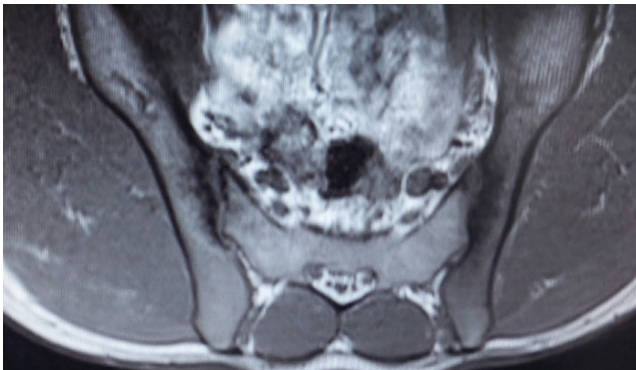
T1-weighted MRI of the sacroiliac joints.
